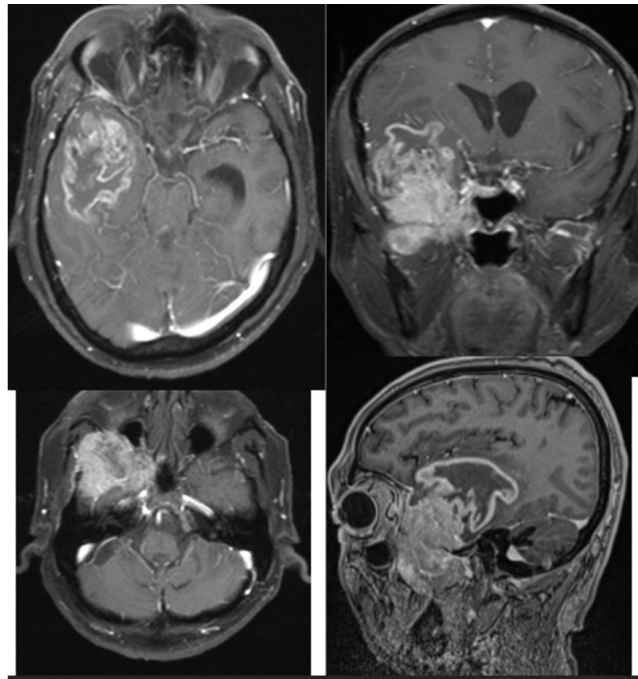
MRI Brain: ill defined heterogenous mass lesion involving right temporal and infratemporal fossa.
